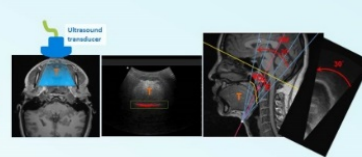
Ultrasound scan of pharyngeal airway: Soft palate (PAL), Lateral pharyngeal wall (LPW), Base of the tongue (BOT), and Epiglottis (E).
